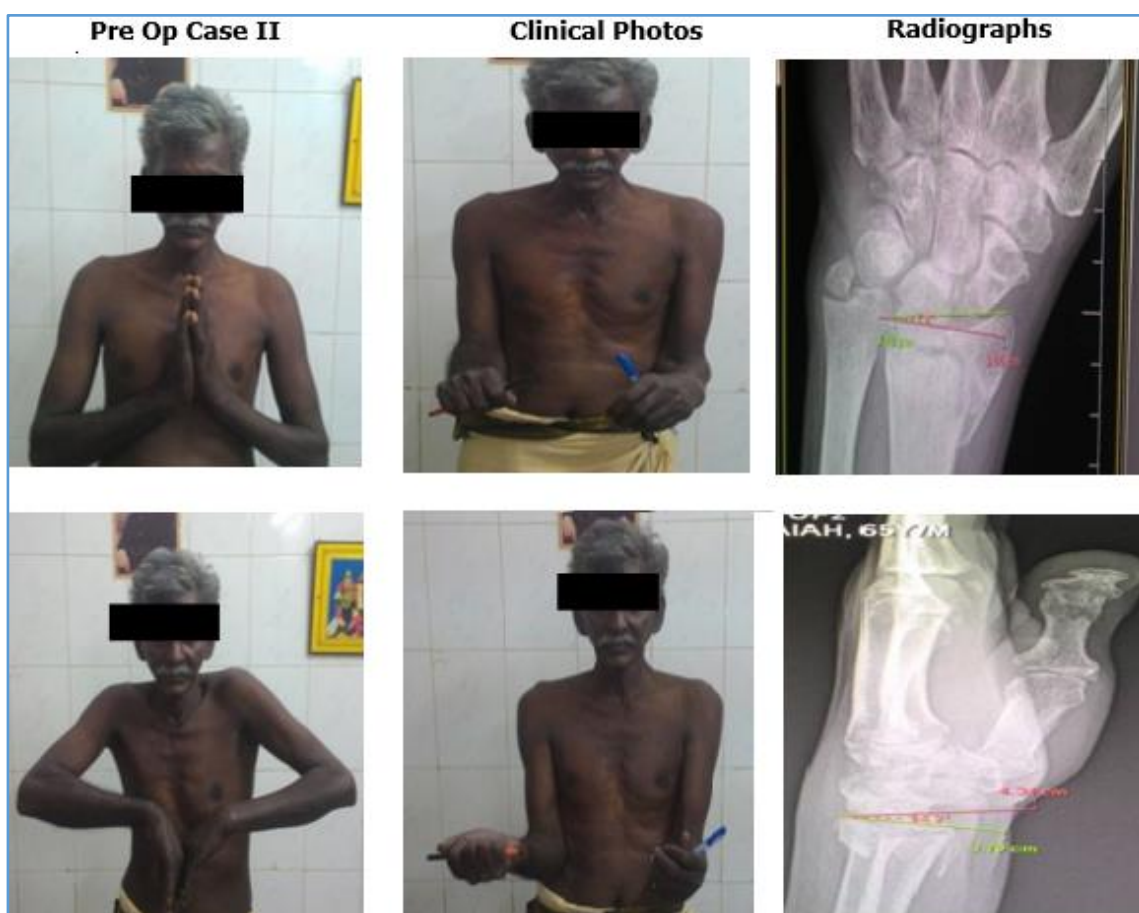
a) Pre op Clinical Photos; b) Radiographs Showing Reduced Radial Length and Dorsal Inclination
